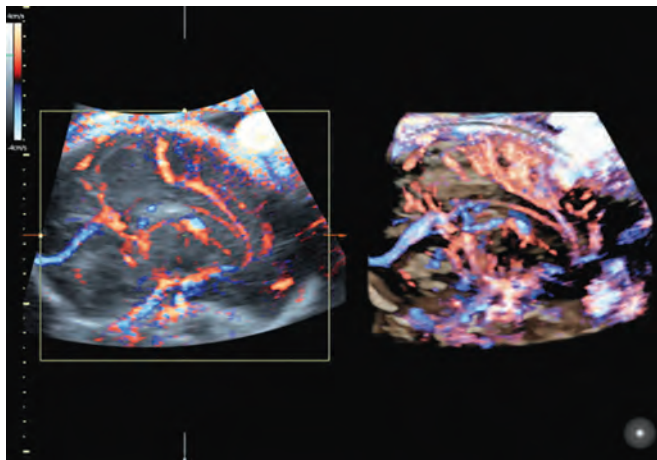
Midsagittal section of the fetal brain acquired three-dimensionally with high-definition power Doppler flow. (A) A glass body rendered image; and (B) the angiography mode rendered image of 20-week-old fetal brain. The images show the entire detailed cerebral vascular anatomy: internal carotid artery; anterior, middle, and posterior cerebral arteries; pericallosal artery, all with their major branches; superior and inferior sagittal sinuses; and vein of Galen
